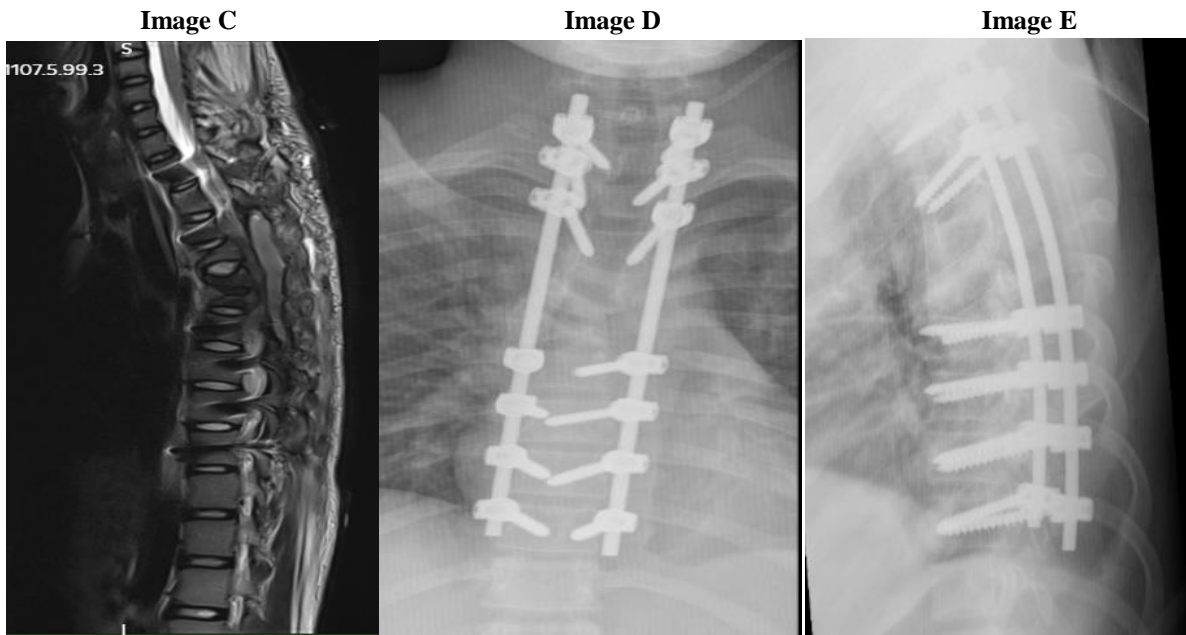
Image C, Image D and Image E: Sagittal T2W MRI, AP and lateral thoracic spine x rays respectively showing control result of first stage of surgery, Shwab 2 osteotomy, pedicle screw/rods fixation from T1 to T10. The allow showing spinal cord compression at T5/T6 level.
